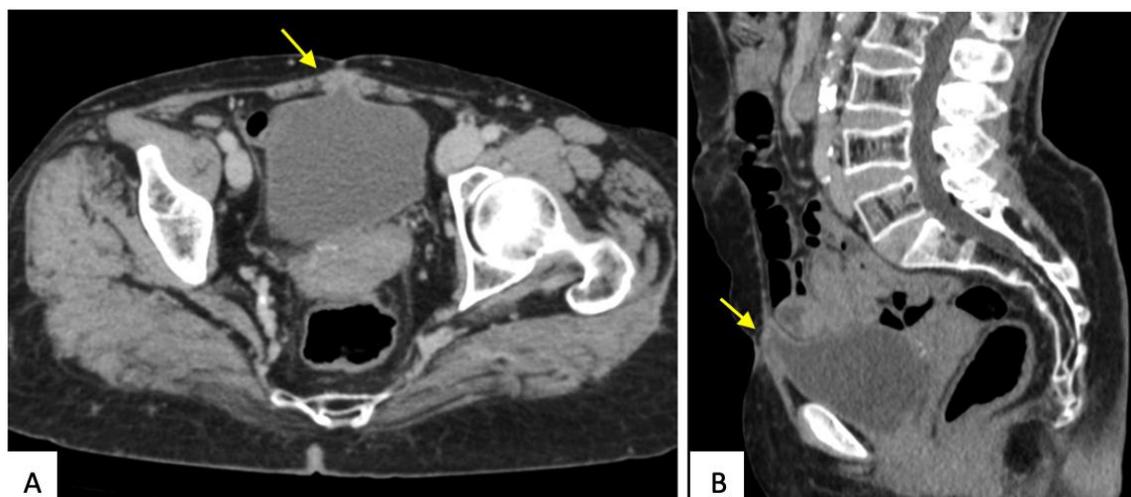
Axial (A) and sagittal (B) CT views showing a communication between the internal end of the urachus and the bladder dome, forming a diverticular structure
